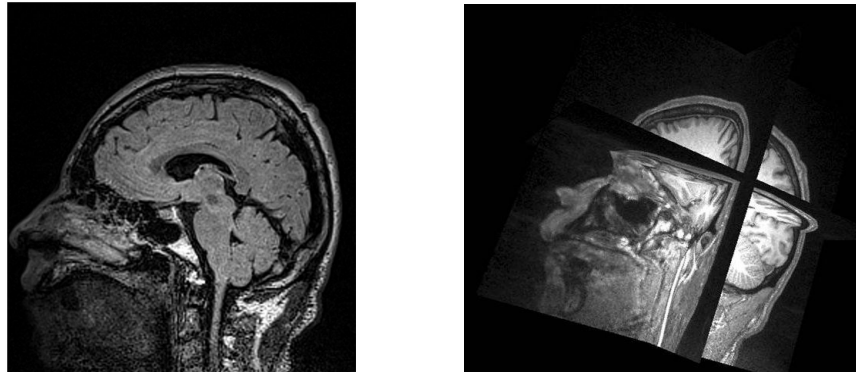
Subject #1 anatomic MRI (left) and 3D reconstruction for segmentation (right).
